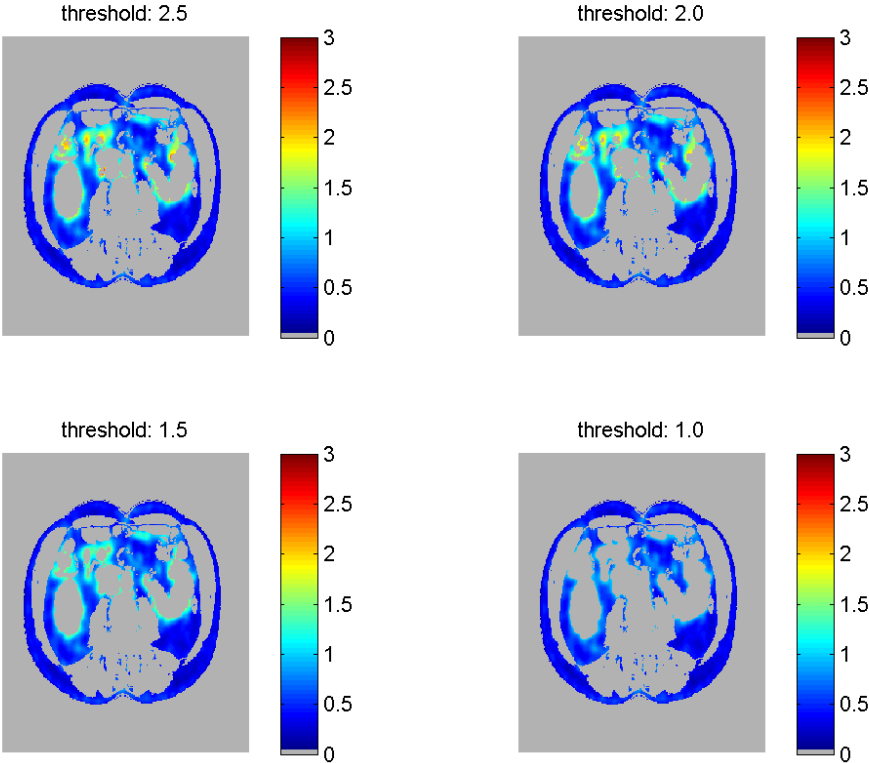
When the threshold is set at 2.5, there is still some spillover detected in the VAT region. For lower thresholds this spillover, together with SUV values from VAT are removed.
